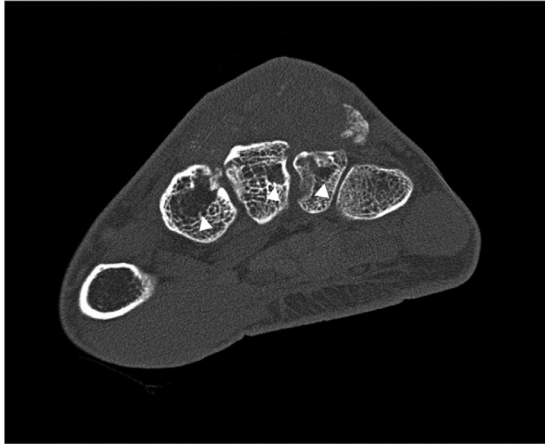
Noncontrast axial CT image shows small lucent lesions (white arrowheads) at the bases of the second, third, and fourth metacarpal bases.
